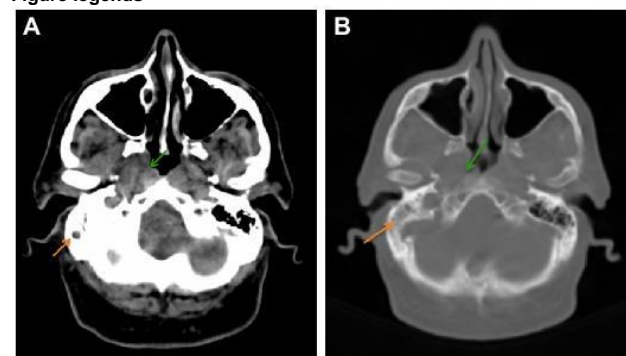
High-resolution computed tomography (CT) revealing a soft-tissue mass filling the right Eustachian tube
